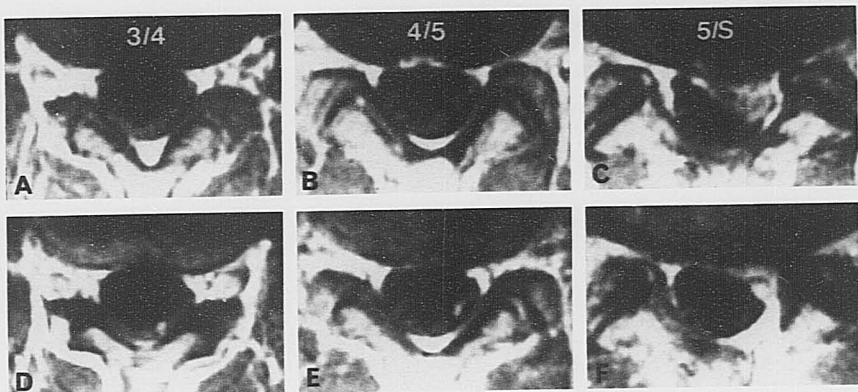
A 31-year-old man with herniation of L5/S1 intervertebral disc in the left side showed radiculopathy of the left S1 nerve root. A-C: Preoperative enhanced MR images do not demonstrate nerve root enhancement. D-F: An enhanced S1 nerve root is seen in postoperative enhanced MR images in spite of relief from radicular pain and neurological recovery.
